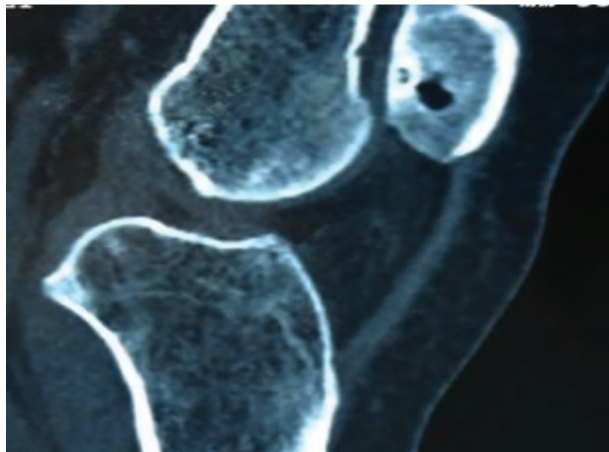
CT scan of the left knee showing the same lesion in the patella.
